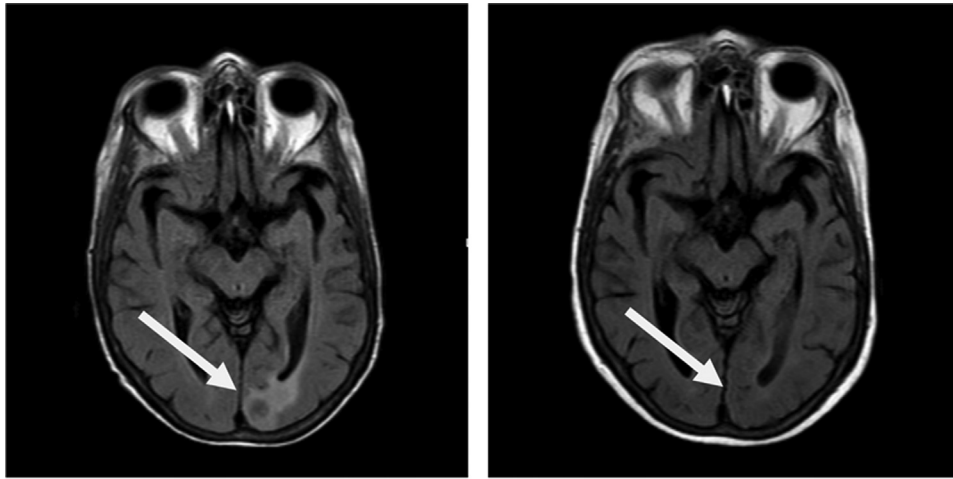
Patient 2, T2-weighted fluid-attenuated inversion recovery magnetic resonance imaging of the brain from before (left) and after 6 weeks of induction antibiotics (right) for *Nocardia nova* (solid arrows).
